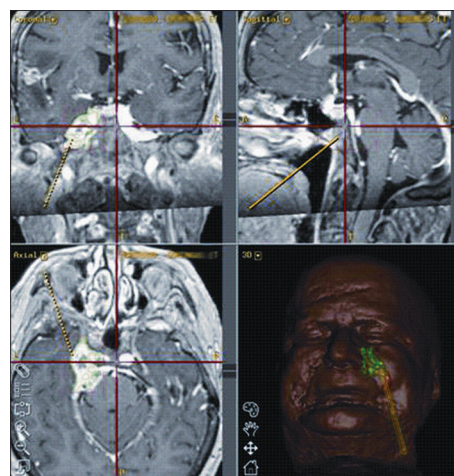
Neuronavigation screenshots demonstrating the capability of multiplanar image reconstruction, which allows for a 3D view of the lesion and needle pathway with image fusion of the CT skull anatomy (foramen ovale) with the MRI image of the lesion, soft tissues, and vessels (carotid artery)
